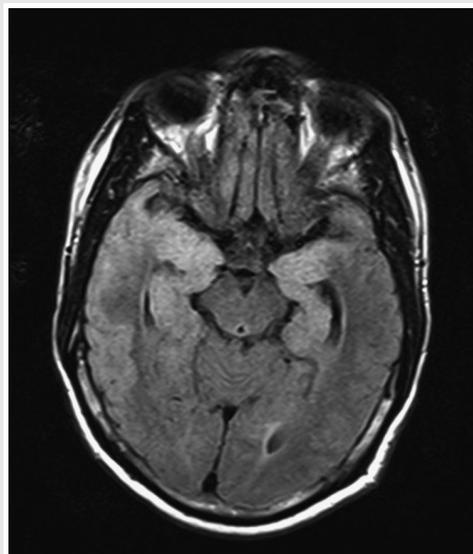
MRI showing temporal lobe and hippocampal involvement suggestive of herpes simplex virus encephalitis in a patient with meningovascular syphilis who presented with stupor.
